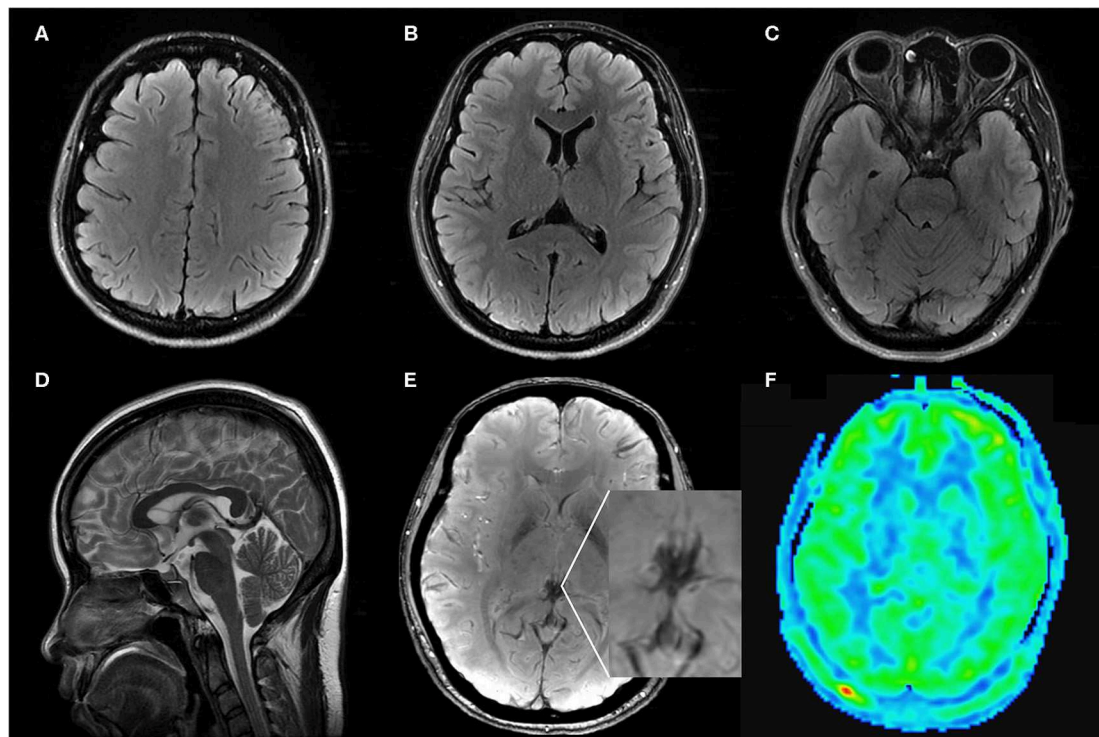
Axial FLAIR (A–C), sagittal T2WI (D), SWI (E), ASL (F) MRI images on follow up: Axial FLAIR imaging demonstrated complete regression of vasogenic edema and convexity SAH. Sagittal T2WI images showed regression of the engorgement of the pituitary and dural sinuses. SWI and ASL images showed the normalization of the signal of the deep venous system and the CBF in bilateral occipitoparietal lobe.
